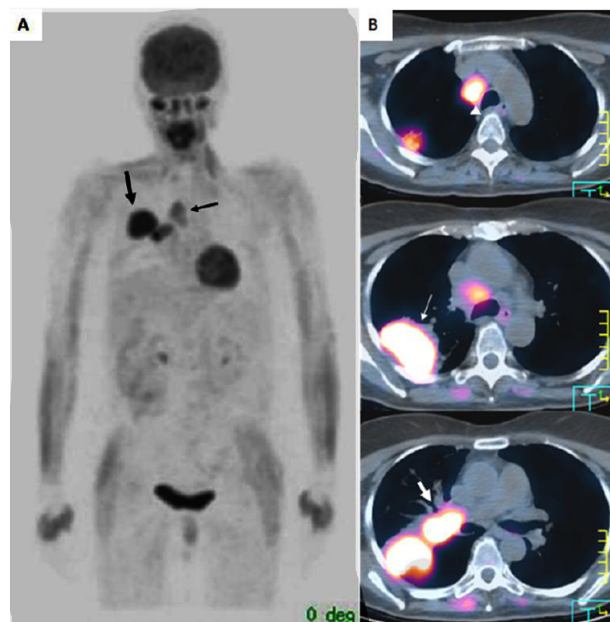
(A-B) - Pre-treatment positron emission tomography/computed tomography (PET-CT) (A) PET whole body image showing an anomalous concentration of 18-fluorodeoxyglucose (18-FDG) in the topography of the right hemithorax (large arrow) and mediastine (thin arrow). (B) PET-CT cross-sectional image showing that the areas of anomalous concentration of 18-FDG correspond to the pulmonary mass (thin arrow), with maximum SUV of 9.68; right paratracheal enlarged lymph node (arrow head) with maximum SUV of 4.07; and right perihilar enlarged lymph node (large arrow), with maximum SUV of 6.88.
